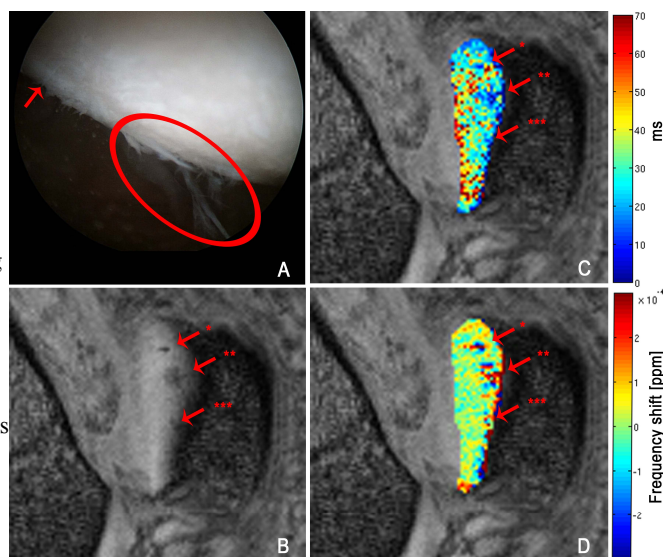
Comparison of arthroscopy (A), average magnitude (B), T2* (C), and frequency (D) of a patient's right patella. Grade III changes marked with arrow and ellipse. Arrows with stars marked MRI abnormalities.
